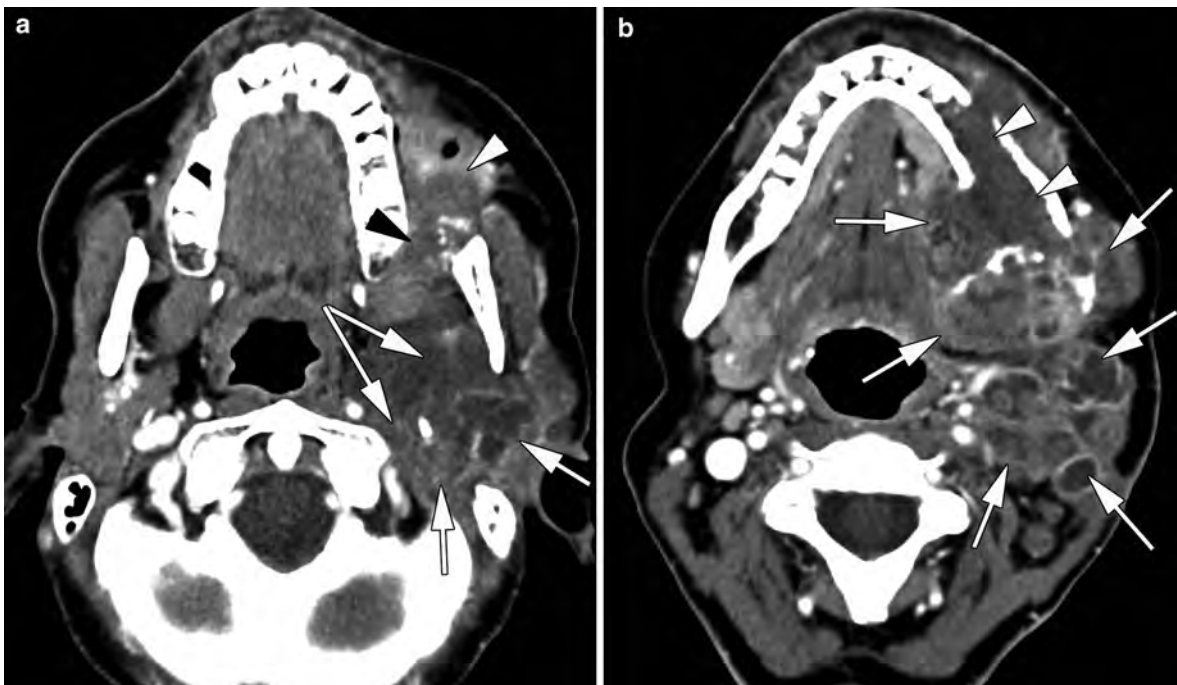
Patient in her fifth decade, with a history of pleomorphic adenoma of the deep lobe of the left parotid gland. After initial resection, a recurrence was resected about 1 year ago. The patient now presents with peri-auricular pain and trismus, and a palpable mass in the pre-auricular and submandibular region. CT shows a large mass lesion in the parotid space, pre- and retro-styloid compartment of the PPS (arrows, a), extending into the masticator and buccinator space (arrowheads, a), and into the floor of the mouth, and peri-jugular and submandibular region
